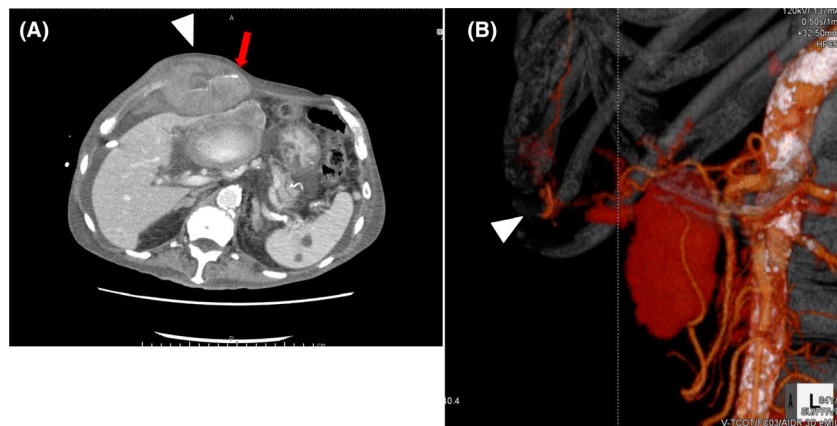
Contrast-enhanced computed tomography carried out 2 days after the second percutaneous catheter drainage of infected liver cysts in an 84-year-old man. A, Abdominal hematoma (white arrowhead). Extravasation of a branch of the right internal mammary artery (red arrow). B, 3-D computed tomography image showing extravasation at the branch of the distal internal mammary artery (white arrowhead).
